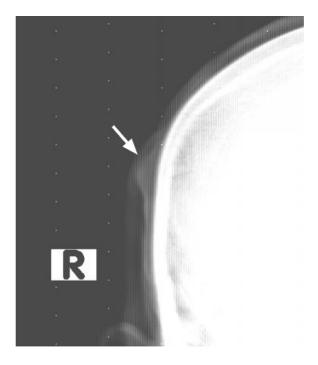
Zoomed and narrowly windowed frontal skull radiograph shows a noncalcified focal swelling in the right lateral scalp (white arrow).
